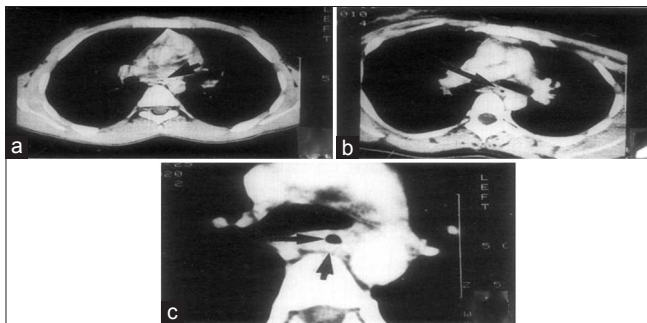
Computed tomography Images of esophageal wall thickness in benign esophageal stricture reproduced from Lahoti *et al.*^[7] (a) Normal esophageal wall (arrow). (b) Mid increase in esophageal wall thickness (arrow). (c) Marked increase in esophageal wall thickness note the esophageal lumen (long arrow) and the outer limit of thickened esophageal wall (short arrow)
